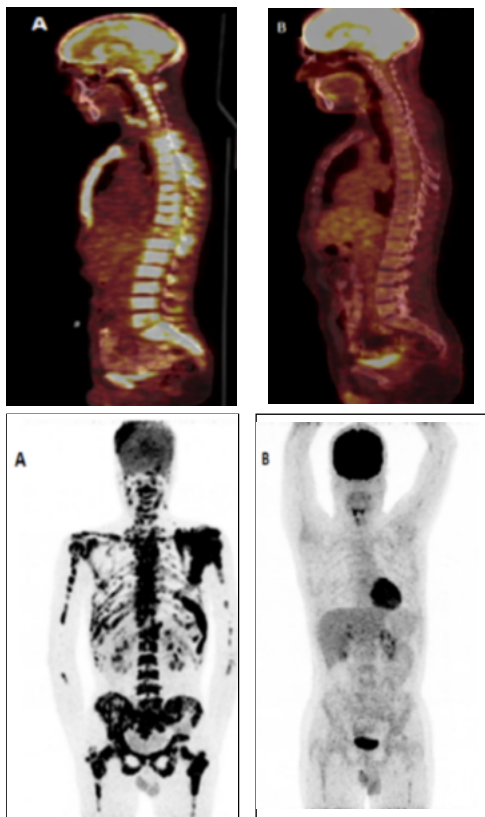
Maximal-intensity projection images obtained with 18F-FDG PET/CT. The abnormally high uptake of 18F-FDG in the skeletal system of the patient was seen in figure 1/A. After six cycles of chemotherapy, there was no uptake of 18F-FDG in the skeletal system of the patient as seen in figure 1/B.
